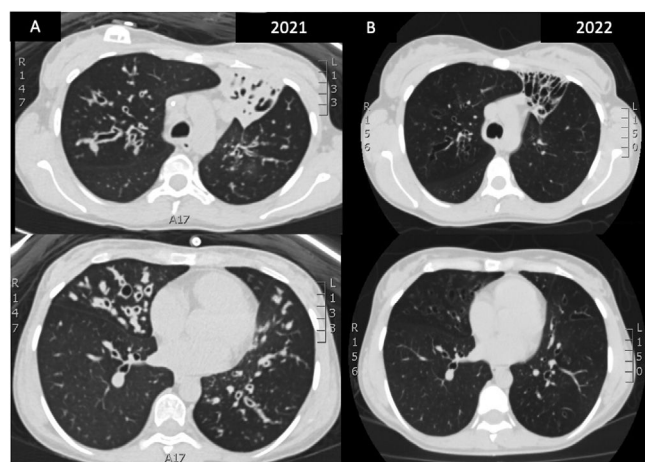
(A) HRCT prior to initiation of treatment: complete atelectasis of the LSI and lingula with beaded and cystic bronchiectasis with severe bronchial thickening. (B) Control HRCT after 18 months of treatment: resolution of mucosal impactions, bronchial thickening and resolution of complete atelectasis in LSI, with beaded bronchiectasis without being occupied by secretions.
